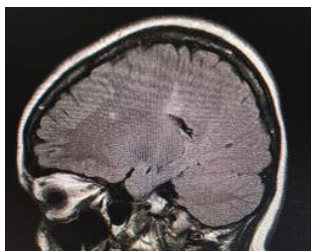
MRI showing demyelinating lesions (hypersignal on T2 and hyposignal on T1) in multiple locations.
